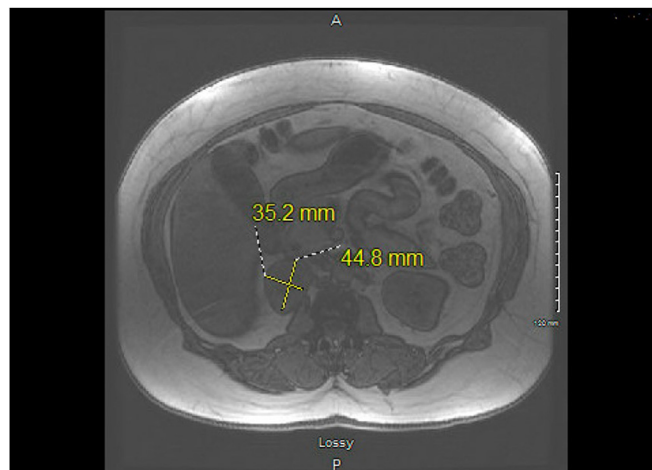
Adrenal magnetic resonance imaging showing the 4.5 × 3.5 cm right adrenal mass.
